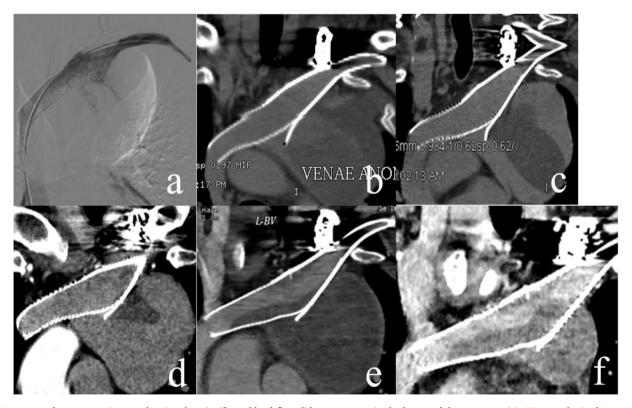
Post-stent placement angiogram showing that significant blood flow did not reappear in the lumen of the aneurysm (a); CT scan obtained 1 month post-treatment showing a complete thrombus within the aneurysm sac (b); CT scan obtained 3–6 months post-treatment showing an additional increase of blood flow in the aneurysm sac (c and d); complete thrombosis within the aneurysm and intraluminal thrombus around the stents found at 12 months (e); significant reduction of the aneurysm and a further increase in the intraluminal thrombus were observed at 18 months.
